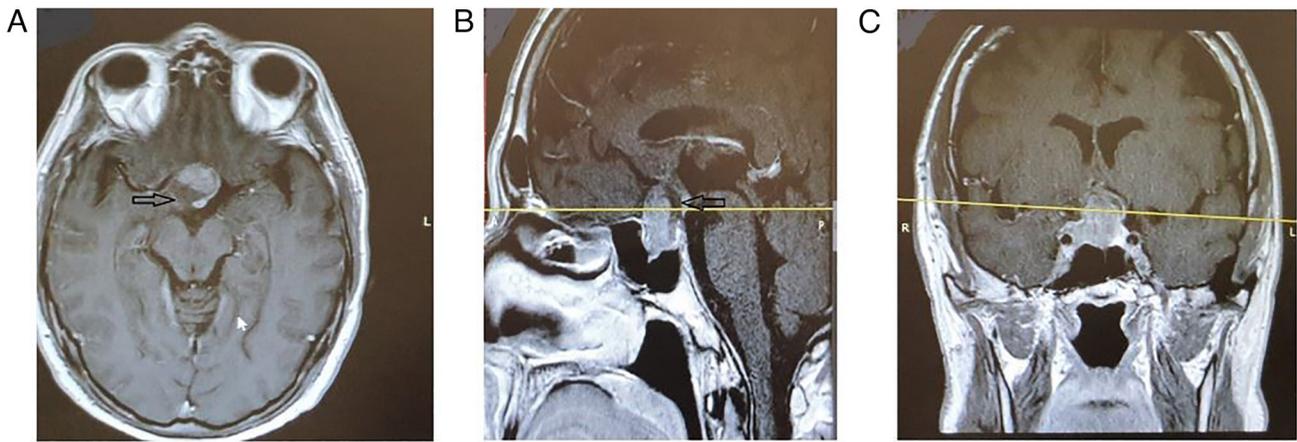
Pre-operative (EET approach) contrast enhanced T1 magnetic resonance image. (A) In the axial cut the tumor was enhanced following gadolinium infusion. Note the low magnetic signal area (arrow), representing hemorrhage due to apoplexy. (B) Sagittal cut in the same patient. The low magnetic signal area in the dorsal part of the tumor (arrow) was caused due to hemorrhage inside the tumor. (C) In the coronal cut, the cranial supra-sellar extension of the tumor compress significantly the optic chiasma.
